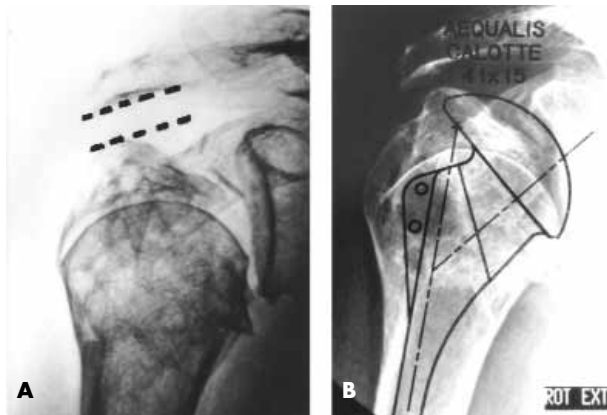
Radiograph demonstrating the false impression of greater tuberosity upward migration in type 1 fracture sequela, due to valgus impaction of the head fragment: measurement of greater tuberosity to acromion distance is normal (A). The radiographic preoperative planning helps to anticipate adaptation of prosthesis to modified anatomy (B).
